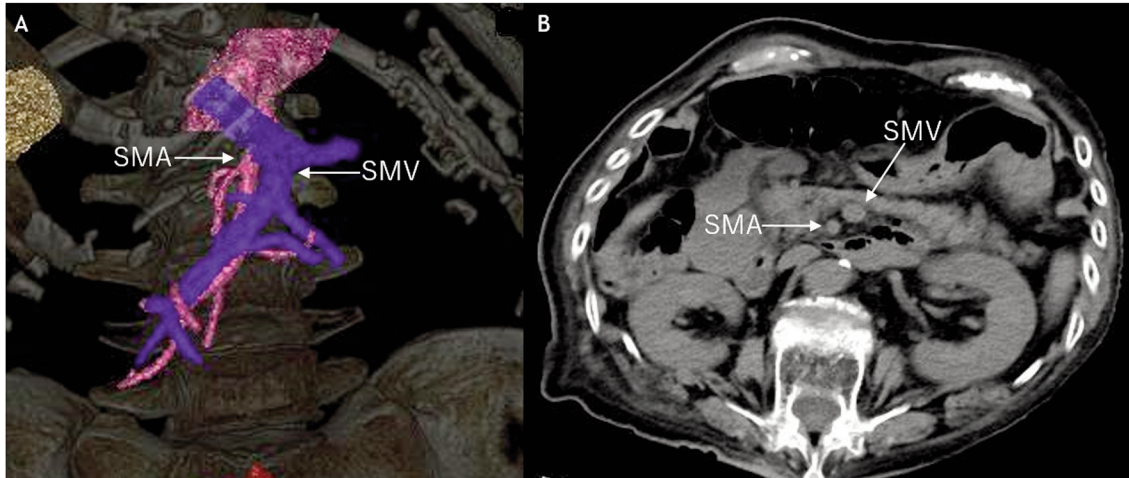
Computed tomography (CT) scan and reconstructed images. A) Three-dimensional CT angiography and B) abdominal CT scan showing superior mesenteric vein (SMV) located on the left side of superior mesenteric artery (SMA).
